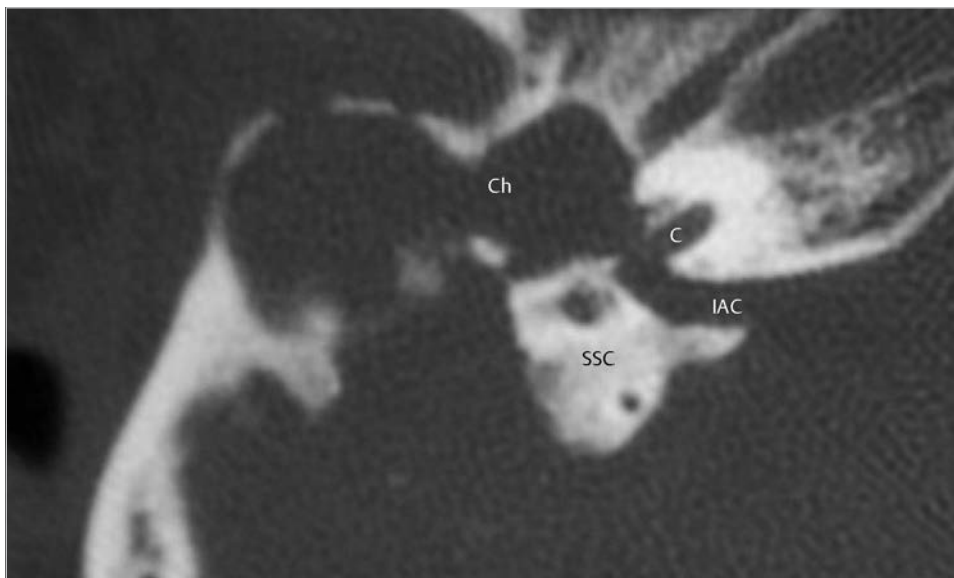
The axial CT shows erosion of the cochlea with involvement of the facial nerve by the cholesteatoma. C, cochlea; Ch, cholesteatoma; IAC, internal auditory canal; SSC, superior semicircular canal.
